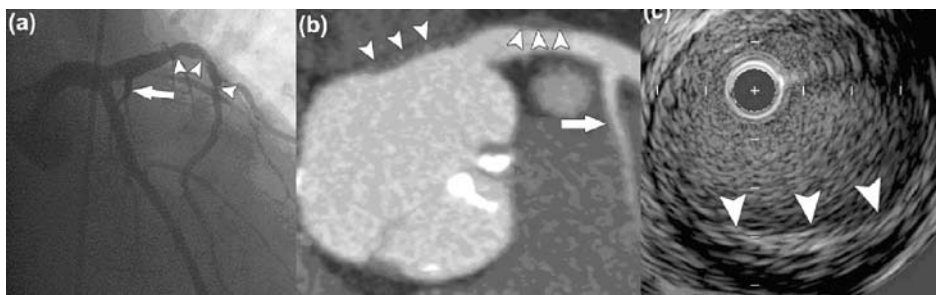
(a) Invasive coronary angiogram showing “wall irregularities” (arrowheads) and thus indirect signs of atherosclerosis distal to the origin of the first septal branch (arrow). (b) Corresponding CT coronary angiogram, maximum intensity projection, showing atherosclerosis (arrowheads) in its earlier stages, i.e. outward remodeling of the vessel without lumen impairment, proximal to the take-off of the first septal branch (arrow). (c) Intravascular ultrasound of the left main stem clearly showing plaque build-up in the intimal layer (arrowheads).
